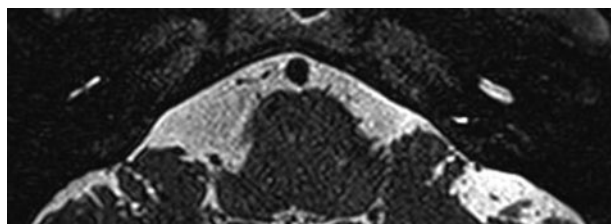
High-resolution T2-weighted magnetic resonance imaging demonstrating abnormally narrowed right basal turn with loss of signal in the region of the scala tympani. Normal left side for comparison.
